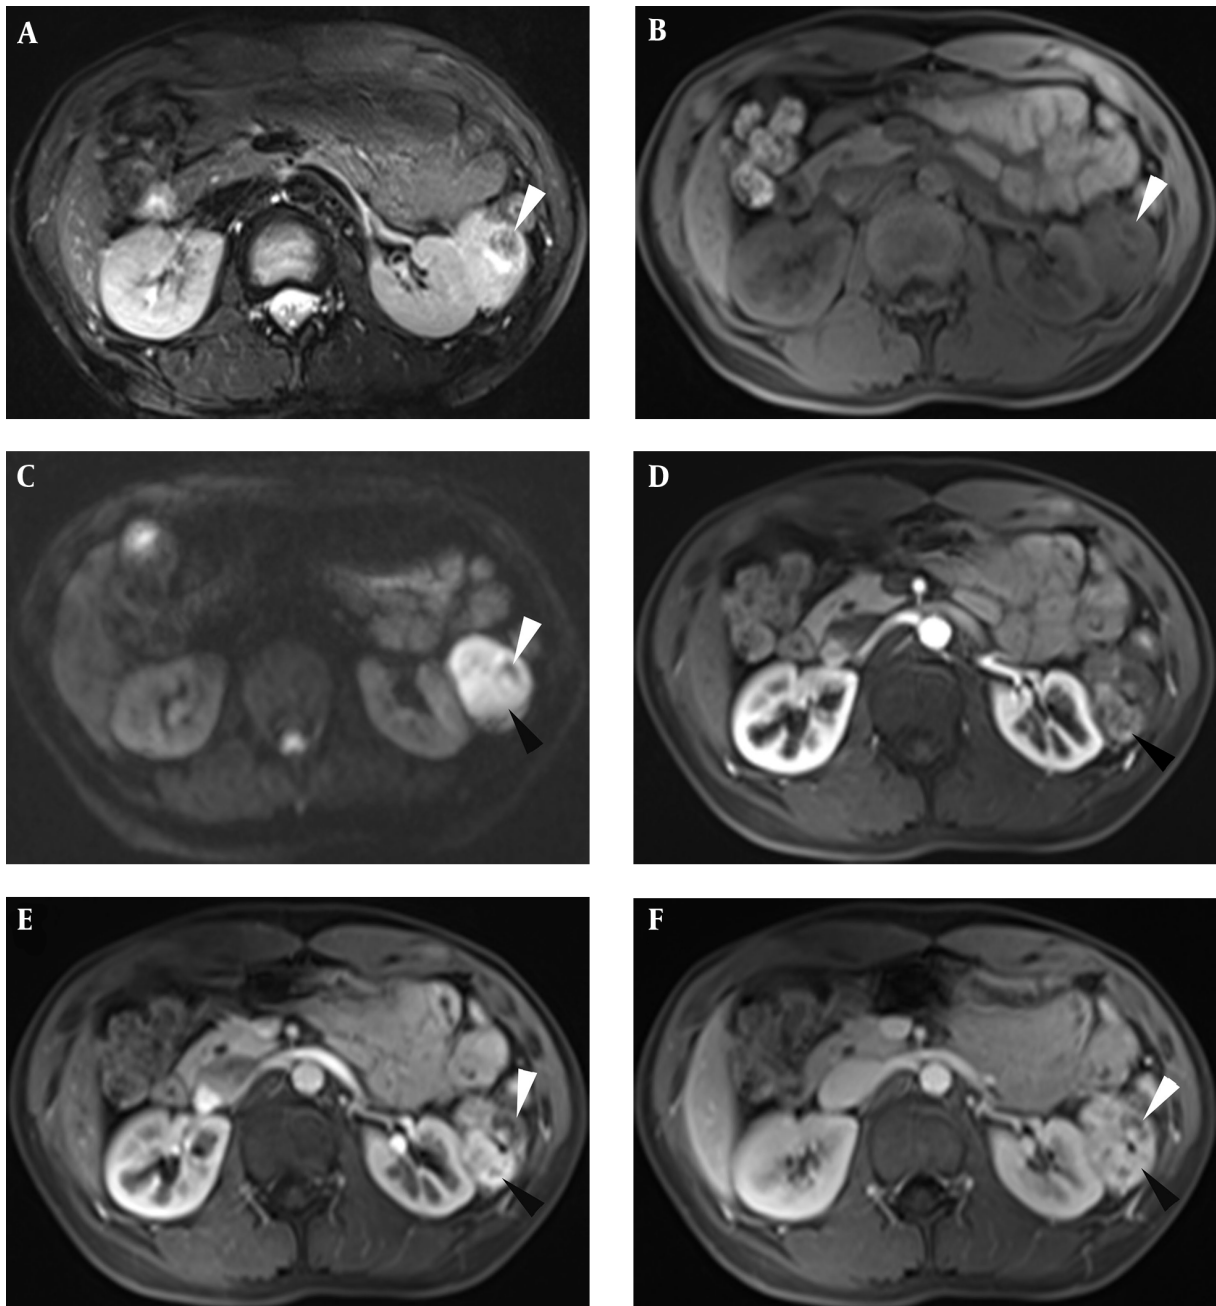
MRI images showing the lesion was heterogeneous hyperintense with nodular hypointense calcium foci (white arrowhead) on T2 weighted image (T2WI) (A), iso-hypointensity with hypointense calcification (white arrowhead) on T1 weighted image (T1WI) (B), and hyperintensity with hypointense calcification on diffusion-weighted imaging (DWI) (C); the parenchyma of the mass showed quick enhancement (black arrowhead) in the arterial phase (D) and vivid enhancement (black arrowhead) in the portal phase (E), along with contrast agent wash out (black arrowhead) in the equilibrium phase (F); the edge of the calcific area showed centrality enhancement (white arrowhead) in the portal phase and equilibrium phase (E and F).
